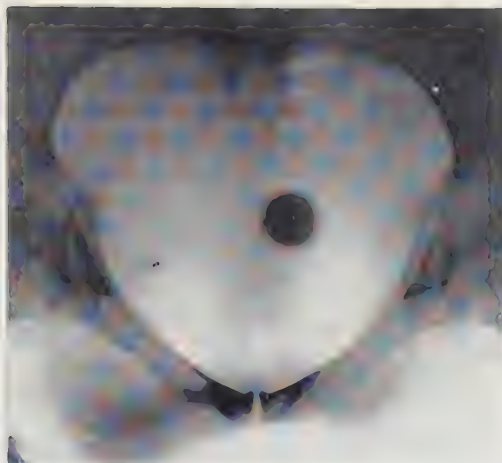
ANDROID PELVIS; X-RAY OF INLET, SHOWING HEART-SHAPED BRIM AND PROMINENT ISCHIAL SPINES.
